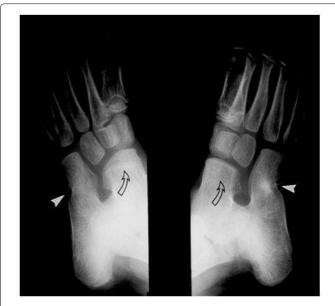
Talonavicular and calcaneocuboid coalitions in a 7-year-old boy. Oblique radiographs of both feet demonstrate bilateral talonavicular (arrows) and calcaneocuboid (arrowheads) coalitions.
